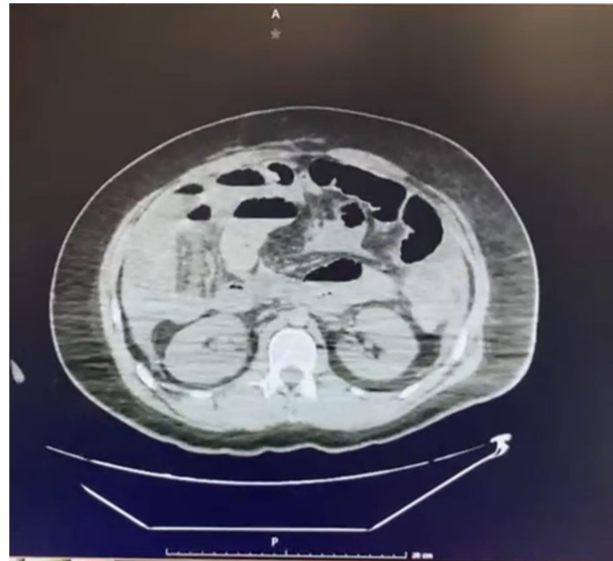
A CT scan was performed in which edema of the intestinal wall was observed, in addition to air-fluid levels and abdominal free fluid.
